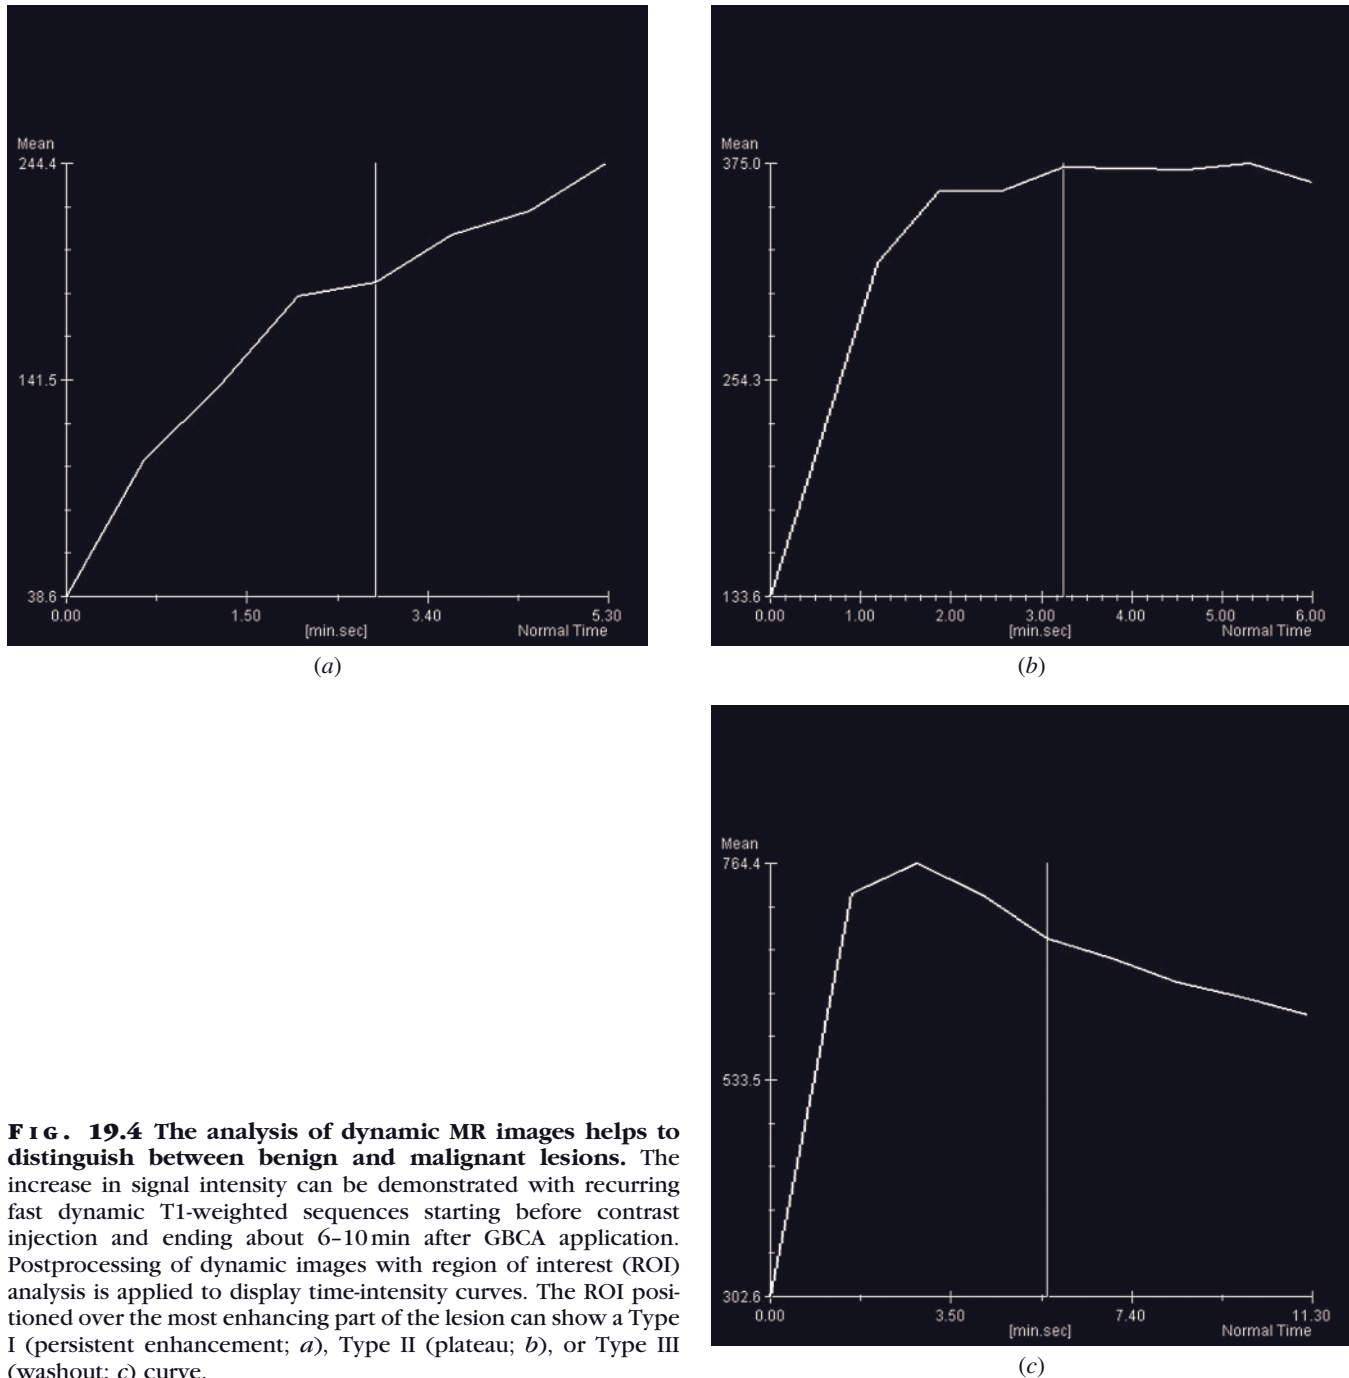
The analysis of dynamic MR images helps to distinguish between benign and malignant lesions. The increase in signal intensity can be demonstrated with recurring fast dynamic T1-weighted sequences starting before contrast injection and ending about 6–10 min after GBCA application. Postprocessing of dynamic images with region of interest (ROI) analysis is applied to display time-intensity curves. The ROI positioned over the most enhancing part of the lesion can show a Type I (persistent enhancement; *a*), Type II (plateau; *b*), or Type III (washout; *c*) curve.
